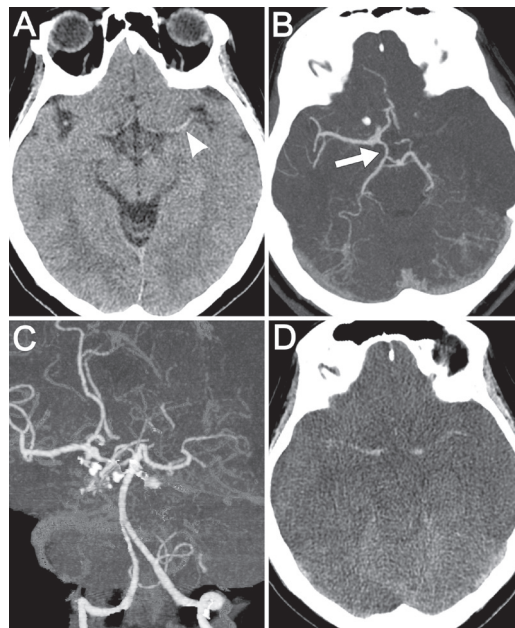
Imaging studies of patient 3 with acute bilateral ICA occlusion. (A) Axial view of brain CT findings on day 1 revealed a sign of hyperdensity of the left MCA (arrowhead). (B and C) CTA on day 1 showed absent bilateral ICAs and left MCA with collateral flow from the right PCA to right MCA (arrow). (D) Brain CT on day 2 revealed acute infarction with diffuse edematous change involving both frontoparietotemporal lobes.
